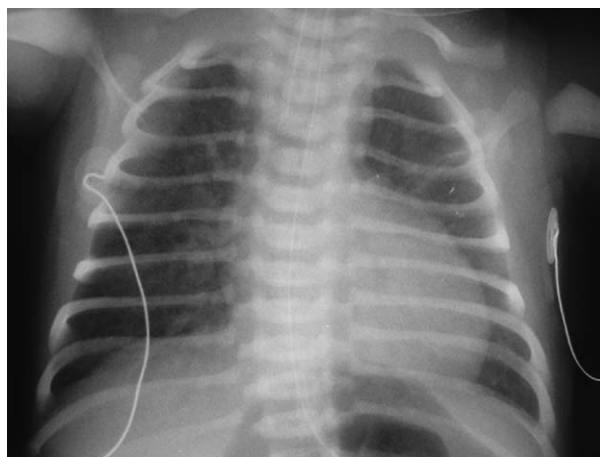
Typical X-ray appearances of transposition of the great arteries (TGA)—cardiomegaly, pulmonary plethora, an egg-shaped heart and a narrow mediastinum, reflecting the abnormal position of the aorta anterior to the pulmonary artery.
